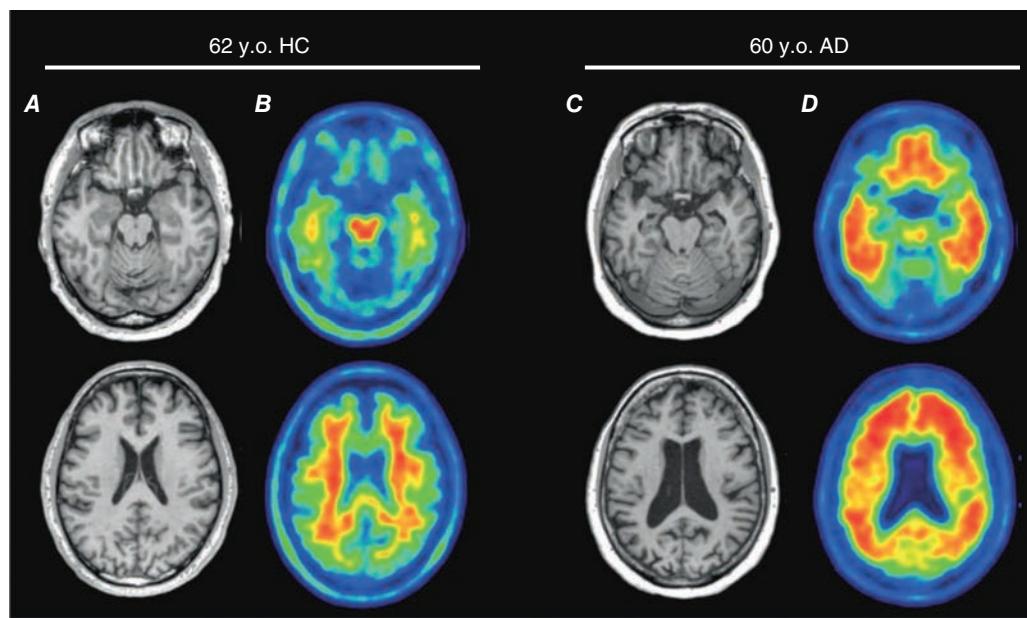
Alzheimer's disease (AD). Axial T1-weighted magnetic resonance images of a healthy 62-year-old (A, B) and a 60-year-old with AD (C, D). Note the diffuse atrophy, plus temporal lobe volume loss, in the patient with AD. A^β positron emission tomography (PET) with [¹¹C]PIB (B and D) reveals extensive radiotracer retention in neocortex bilaterally in AD, consistent with the known distribution of amyloid plaques. HC, healthy control. (Source: Gil Rabinovici, University of California, San Francisco and William Jagust, University of California, Berkeley.)
